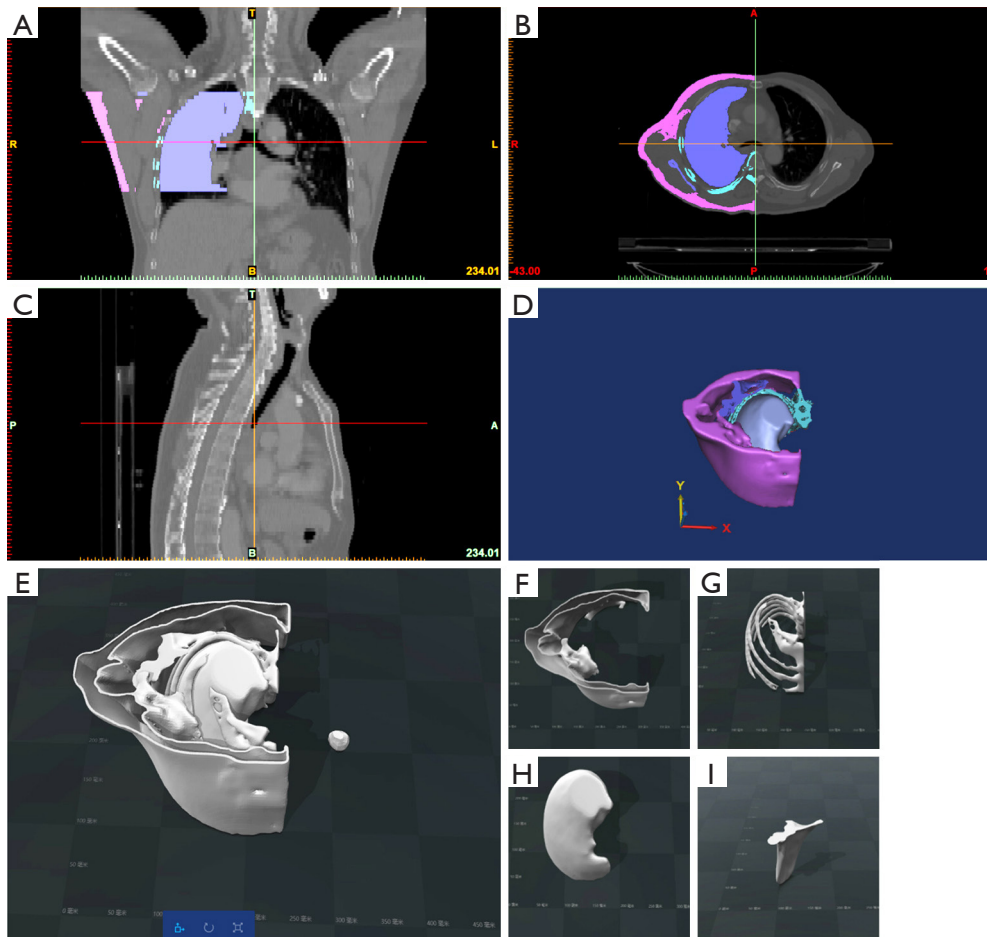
The regions of interest in patient CT data were processed by Mimics Research 17.0 (deep purple part represents lesions). (A) Coronal section; (B) transverse section; (C) sagittal plane; (D) 3D reconstruction; (E) the shell model of the muscle tissue opened up, the lung tissue shell model opened downward, and the rib model wrapped around the lung tissue model; (F) the shell model of muscle tissue (opening upwards); (G) the ribs and chest bone model; (H) the lung tissue shell model (opening downward); (I) the scapula model.
